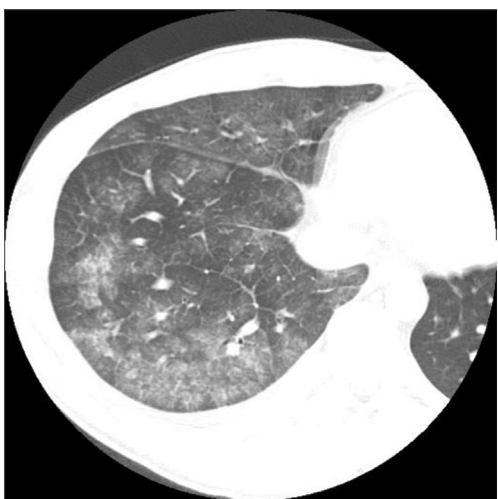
Chest CT image of a patient with AEP. A 21-years old man showed diffuse ground glass opacities together interlobular septal thickening (presented right lower and middle lobe).
